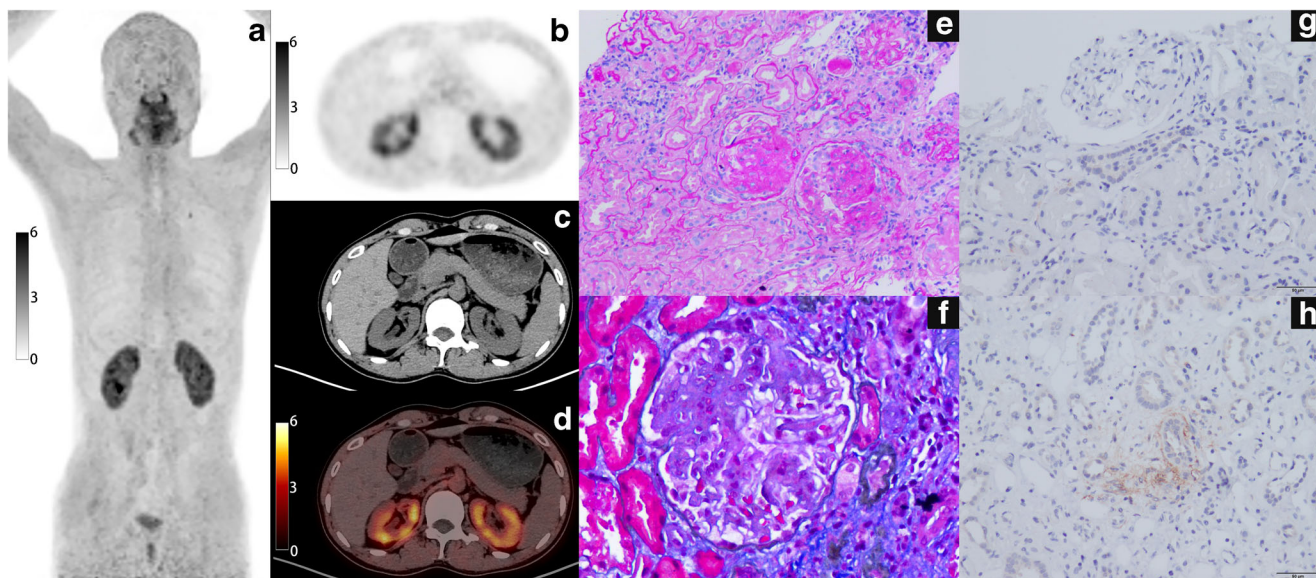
A 25-year-old man had decreased renal function and proteinuria during a physical examination more than 3 months ago. The maximum intensity projection (MIP) image of whole-body [^{68}Ga]Ga-FAPI-04 PET (a) shows diffuse radiotracer uptake in both kidneys. The cross-sectional images (b–d) show light radiotracer uptake in both kidney parenchyma, and the SUVmax was 7.6, suggesting diffuse fibrosis of the kidneys. The
